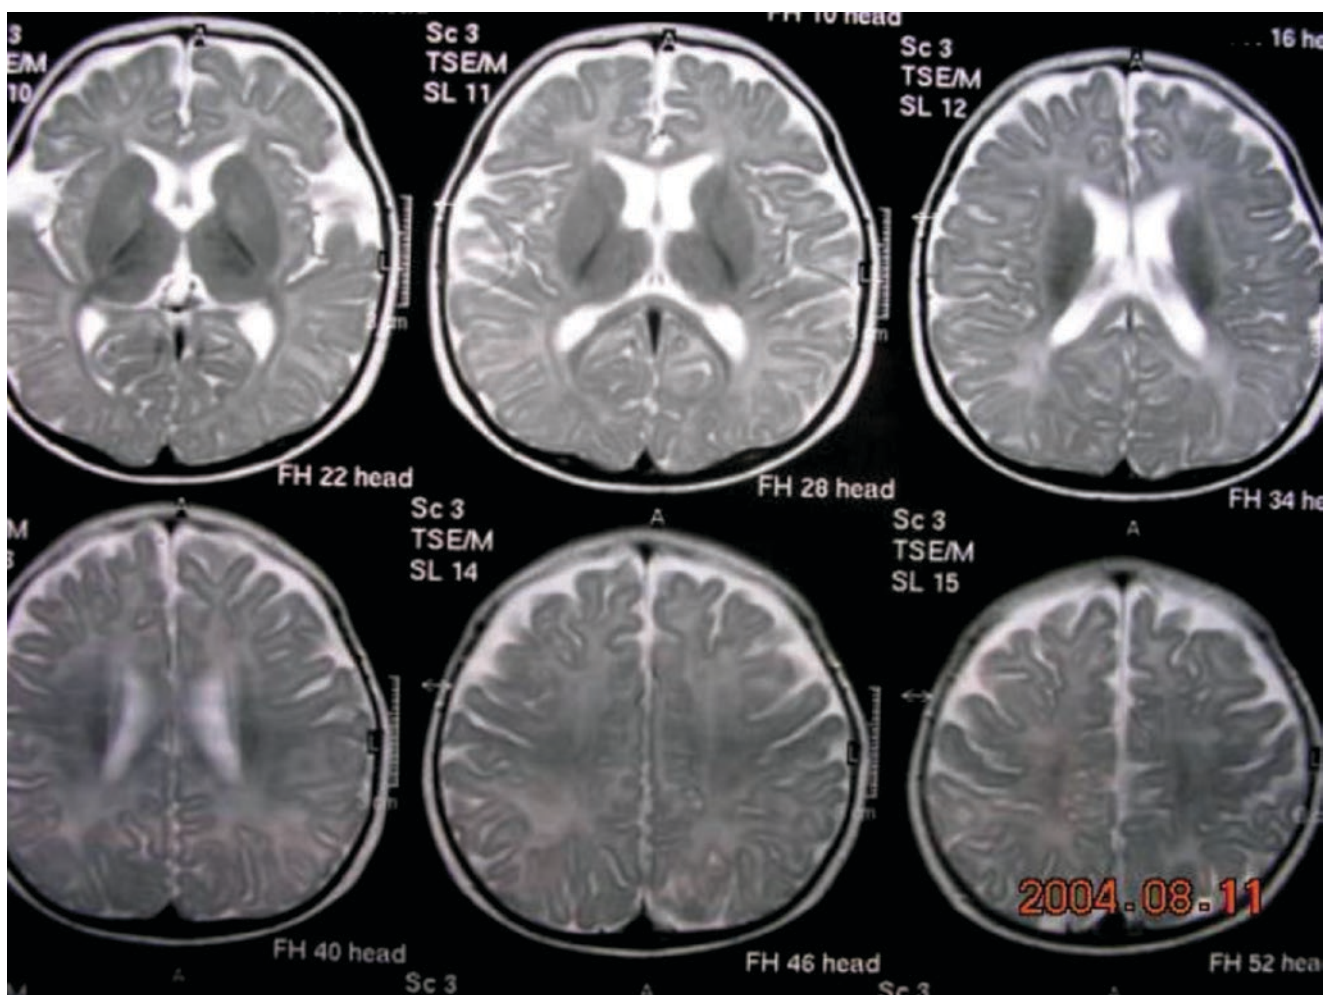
MRI findings of PVL
